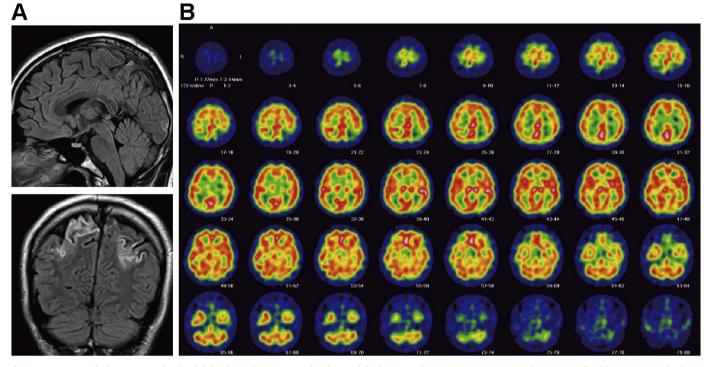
Neuroimaging findings associated within left-hand agraphia. (A) Sagittal and coronal fluid attenuated inversion recovery images showing no callosal lesions. (B) Single-photon emission computed tomography showing selective hypoperfusion in the left superior parietal region.
